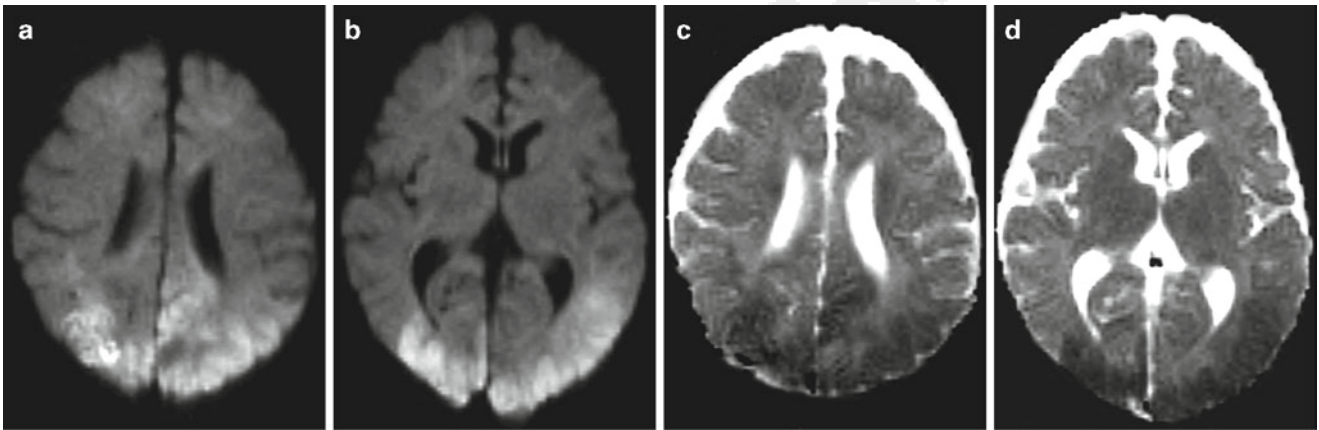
Hypoglycemic encephalopathy. (a, b) Axial DWI and (c, d) ADC images from a 3-month-old boy with severe hypoglycemia demonstrate markedly restricted diffusion in the occipital and parietal lobes bilaterally
